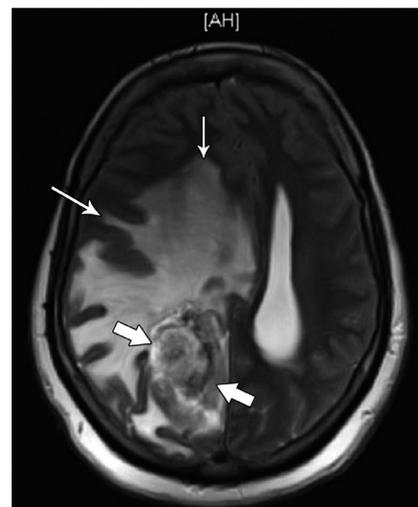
Brain MRI showed minimal interval progression in the tumor component (wide arrows) and progression of the surrounding edema (narrow arrows).
